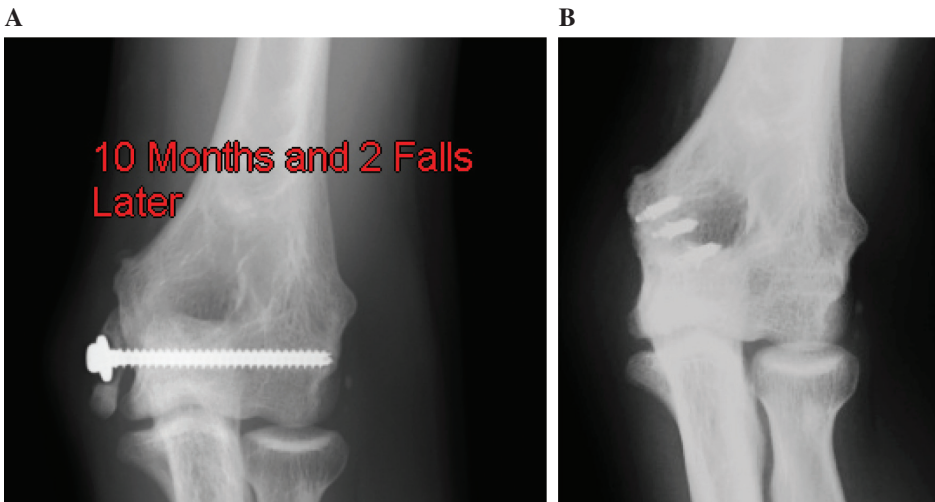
The patient from figure 5 presented 10 months following surgery with pain and medial prominence following return to wrestling. Radiographs demonstrate fragmentation and displacement of the medial epicondyle (A). He underwent a removal of hardware with excision of the osseous fragment and repair of flexor pronator mass and medial ligamentous structures to the distal humerus via multiple suture anchors (B).
